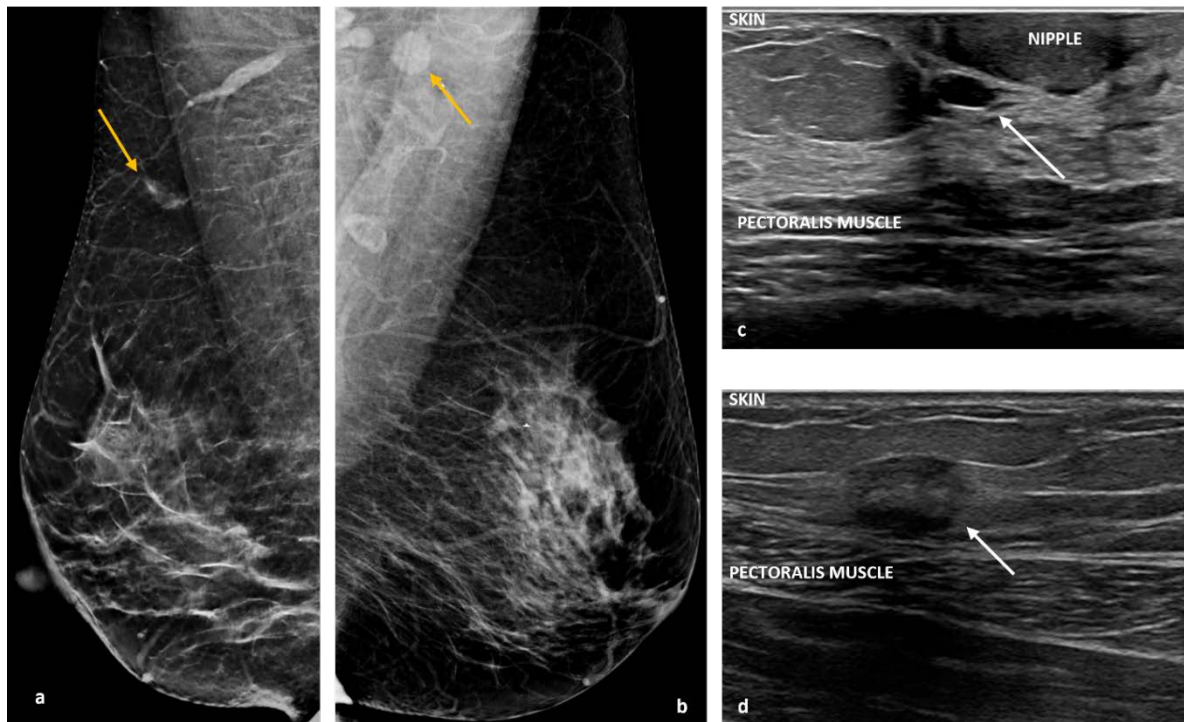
Imaging features of granular cell tumors in the breast on mammography and ultrasound: All different patients. Granular cell tumors can present as masses with non-circumscribed – (indistinct) margins (6a) or circumscribed margins (6b). Their location can be superficial - subcutaneous (6c) or deep, abutting the pectoralis major muscle (6d).
